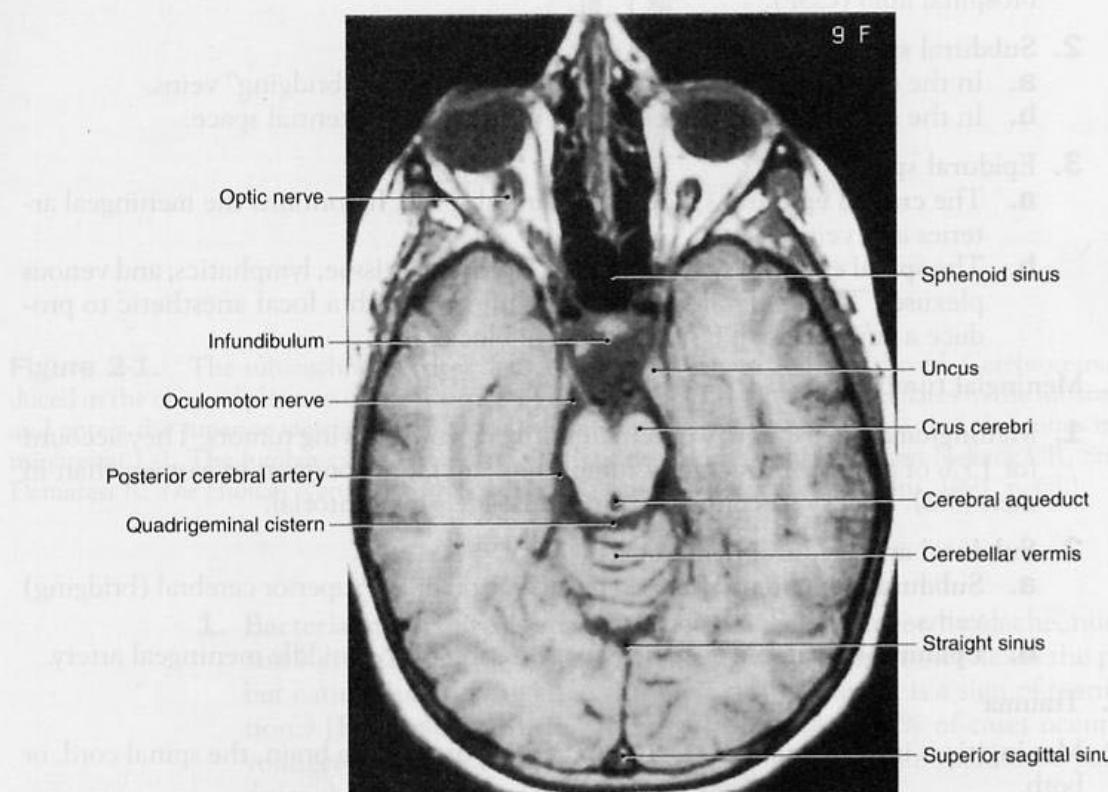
Axial magnetic resonance imaging section at the level of the uncal incisure, oculomotor nerve, and inferior colliculus. Is there pathology within the orbit?
